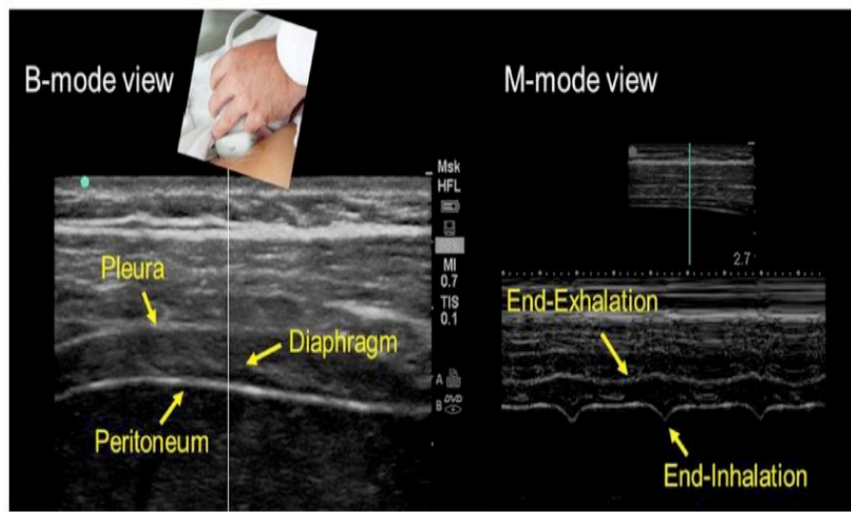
Diaphragmatic ultrasound
